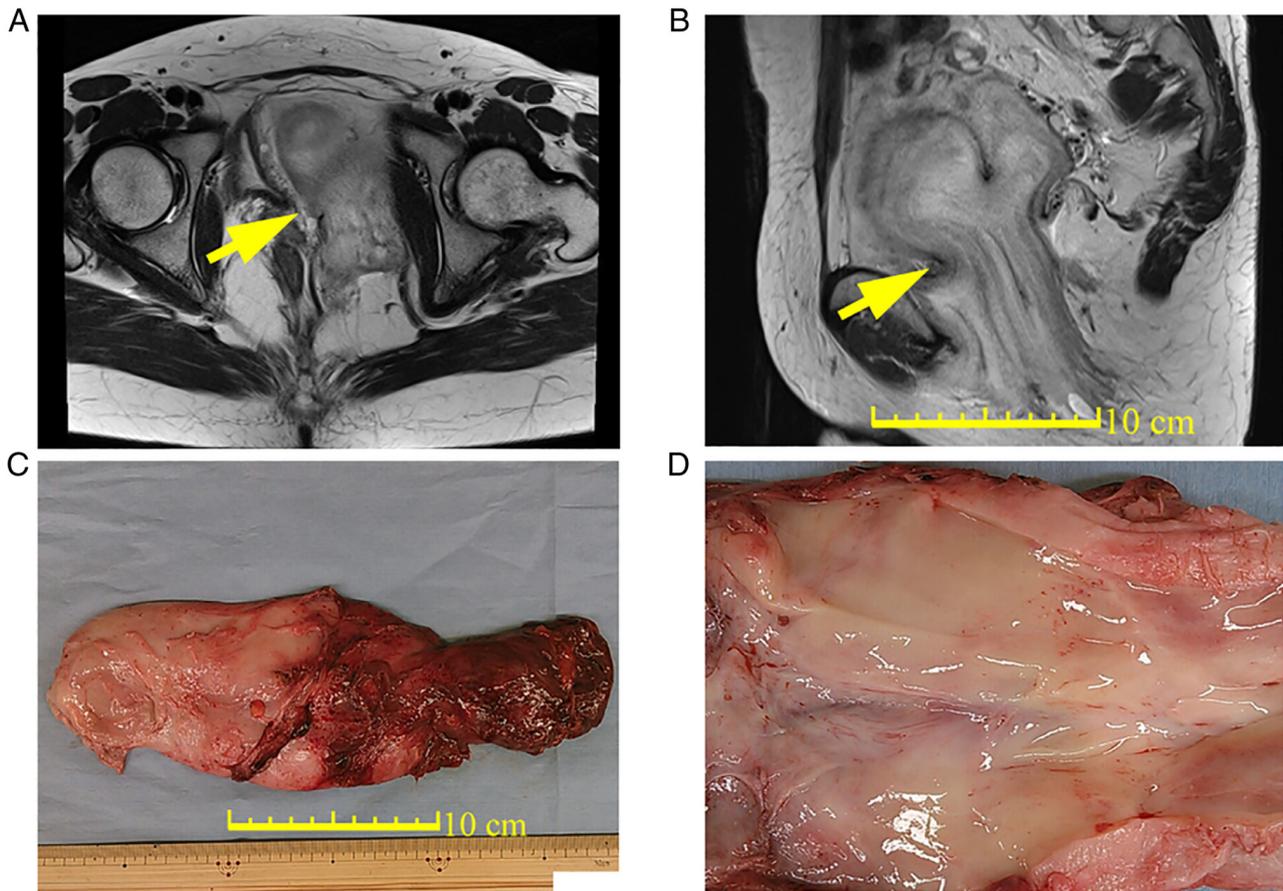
Imaging and gross pathology of the deep angiomyxoma. (A) Axial, enhanced, T2-weighted MRI scan indicating a high-signal intensity tumor displacing the pelvic organs to the right (arrow). (B) Sagittal, enhanced, T2-weighted MRI scan indicating a 14-cm in the longest axis, nodular, structured tumor extending from the vulva to the paravesical space with swirled and layered strands of lower signal intensity (arrow). (C) The gross appearance is elastoplastic and soft, with a glistening and gelatinous surface. (D) Close-up of C.
